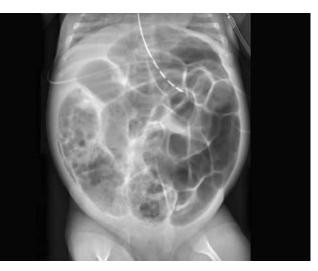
Abdominal radiograph of a preterm newborn with necrotizing enterocolitis. Note the distended air-filled loops of large and small bowel. Significant pneumatosis intestinalis, which is intramural bowel gas, is visualized within the right lower quadrant and within the pelvis. Not seen here, an associated finding is air in the portal veins of the liver.
